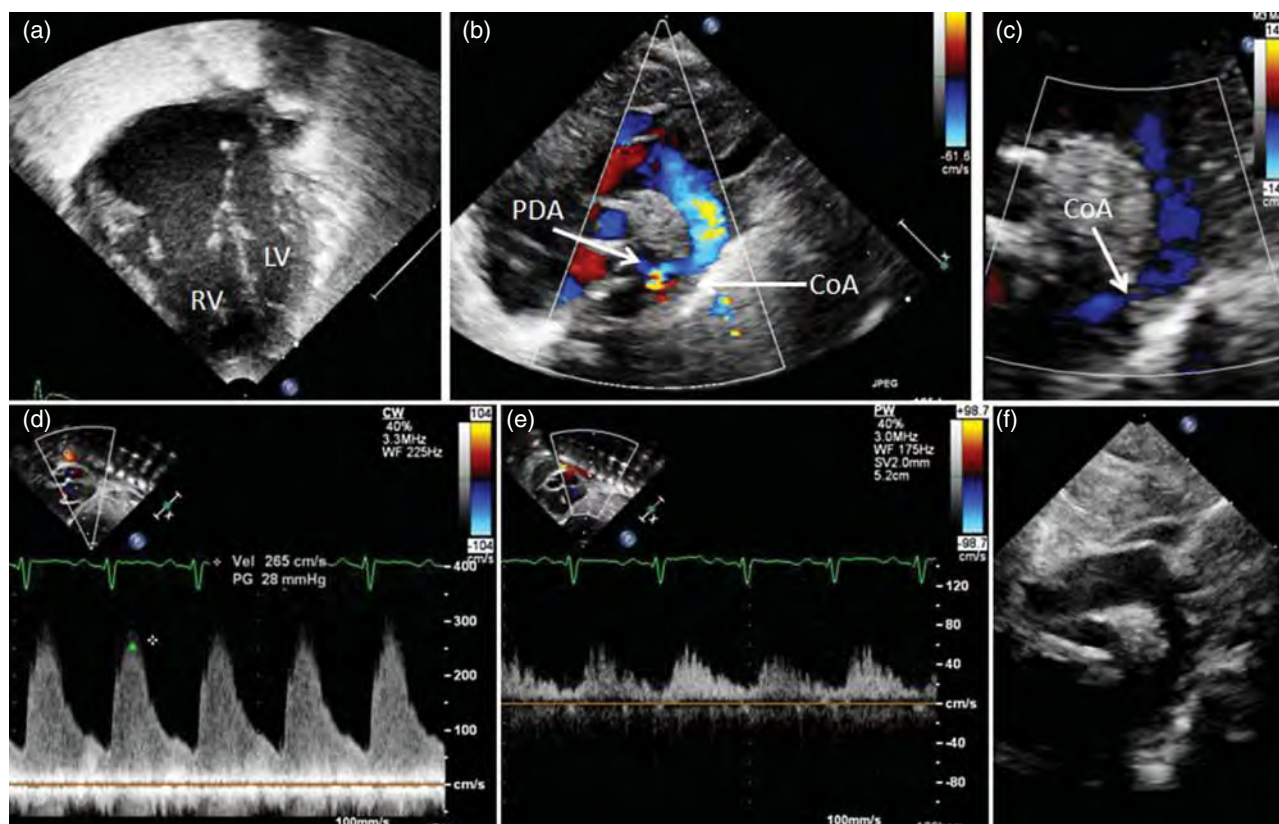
Series of postnatal echocardiography images from a patient with coarctation of the aorta (CoA): (a) four-chamber view with marked right ventricular dilation; (b) color flow mapping showing narrowing of the isthmus, patent ductus arteriosus (PDA), and posterior shelf; (c) magnified image of the narrowed segment showing the posterior shelf; (d) spectral Doppler at the site of narrowing with a significant pressure gradient and diastolic tail; (e) spectral Doppler of the abdominal aorta showing low velocity flow, increase in deceleration time, and diastolic tailing; (f) aortic arch status after extended end-to-end anastomosis repair.
